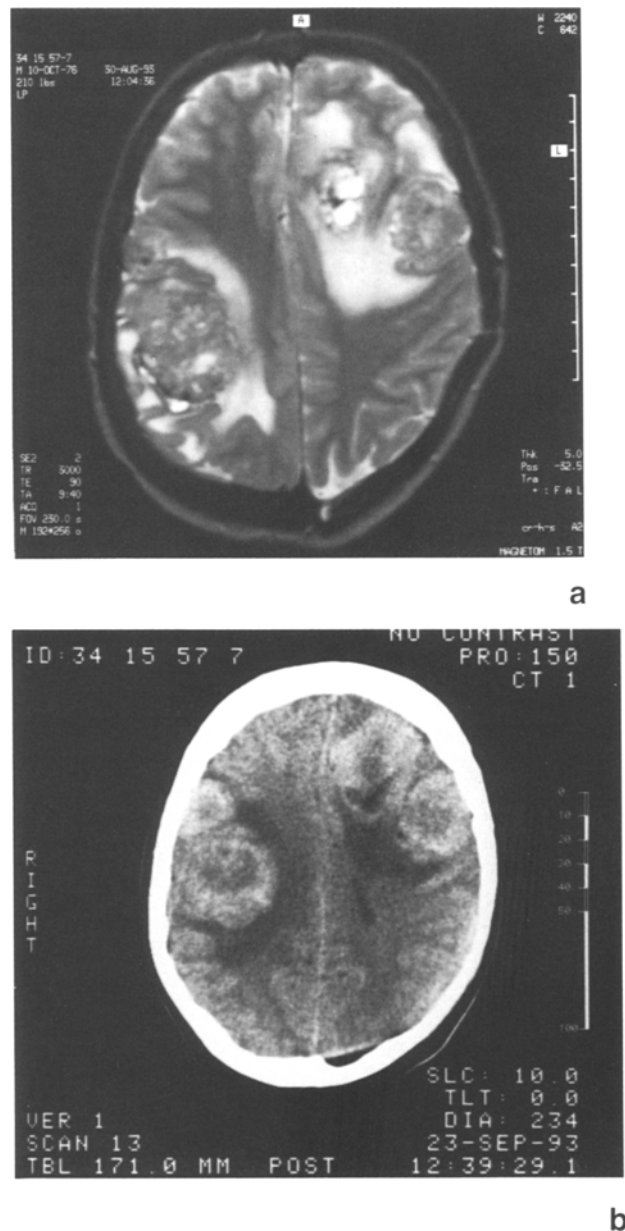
(a, b) T-2 weighted axial MR image (a), and axial CT scan of the brain show multiple intracranial parenchymal metastases in the malignant melanoma case
